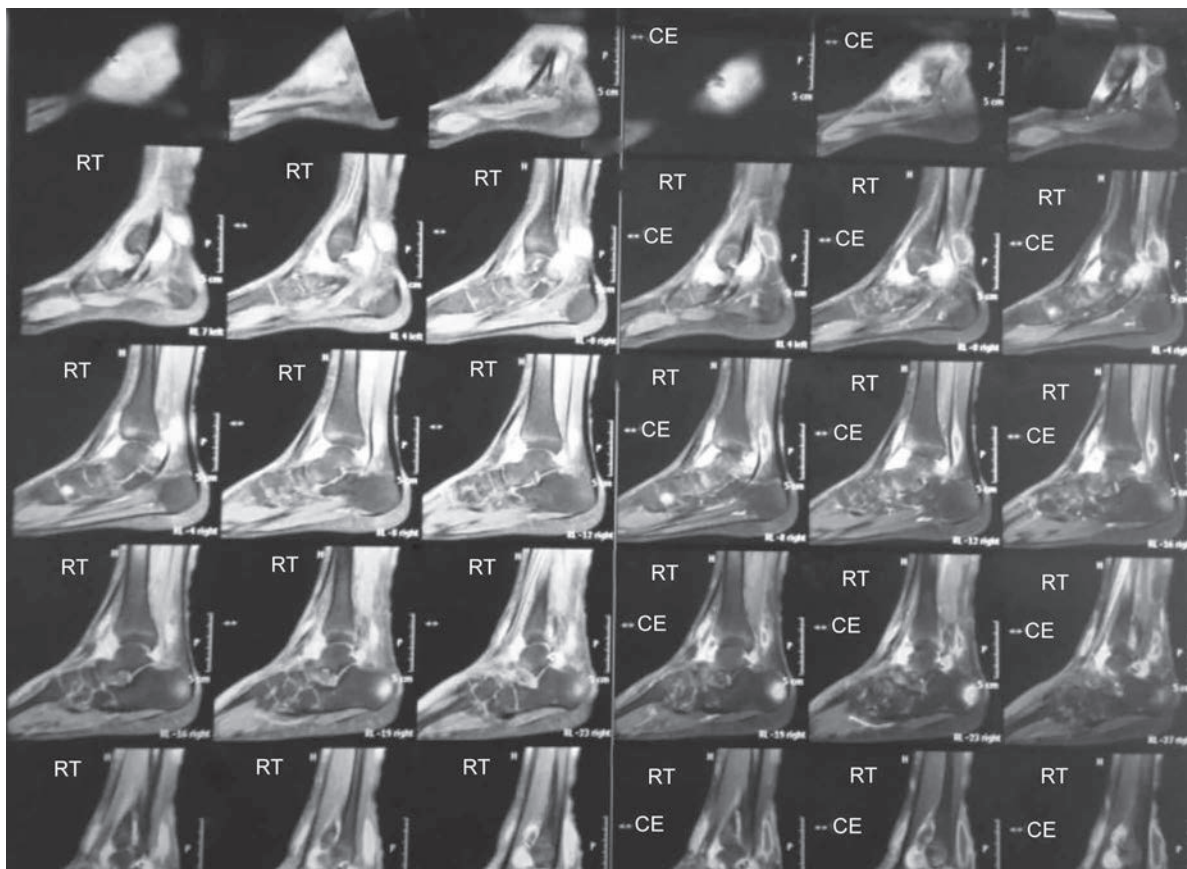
MRI findings suggestive of abscess collection around ankle joint with confluent areas of marrow edema in talus, all cuneiforms, cuboid, navicular and base of metatarsal bones due to infective etiology most likely (Case 1)
